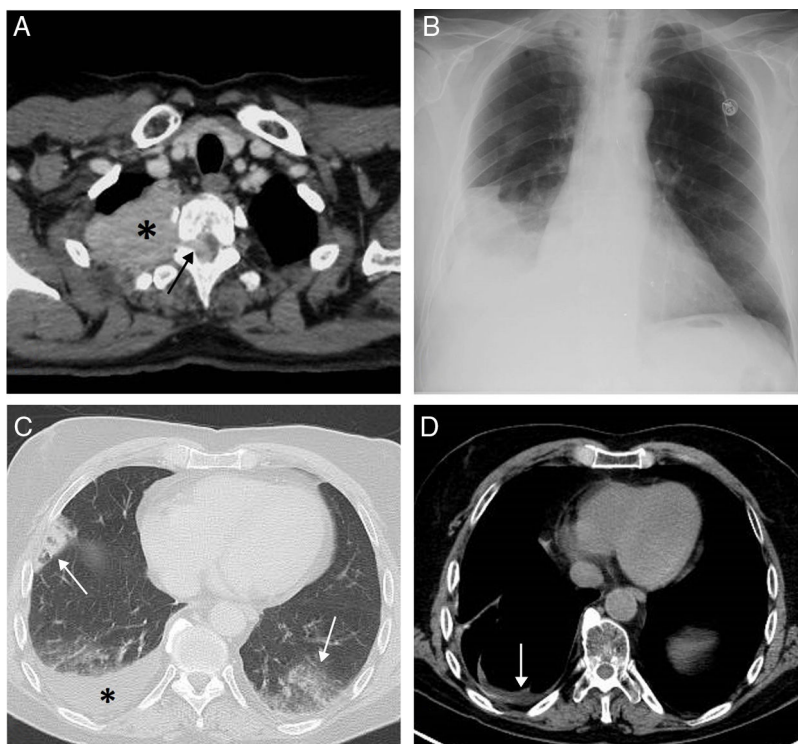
(A) Axial CT scan of the chest (mediastinum window) performed in 2012 that identifies a solid mass in the upper right hemithorax (asterisk) infiltrating the chest wall and penetrating the spinal canal through the right T2–T3 intervertebral foramen (arrow). (B) Posteroanterior chest X-ray performed in November 2017 showing right pleural effusion for the first time in this patient. (C) Chest axial image of a PET/CT scan performed in November 2017 which identifies bilateral opacities of pneumonic aspect (arrows) and right pleural effusion (asterisk). (D) Thoracic axial image of another PET/CT scan performed in March 2018 which shows the disappearance of pneumonic opacities and the presence of minimal pleural effusion.
